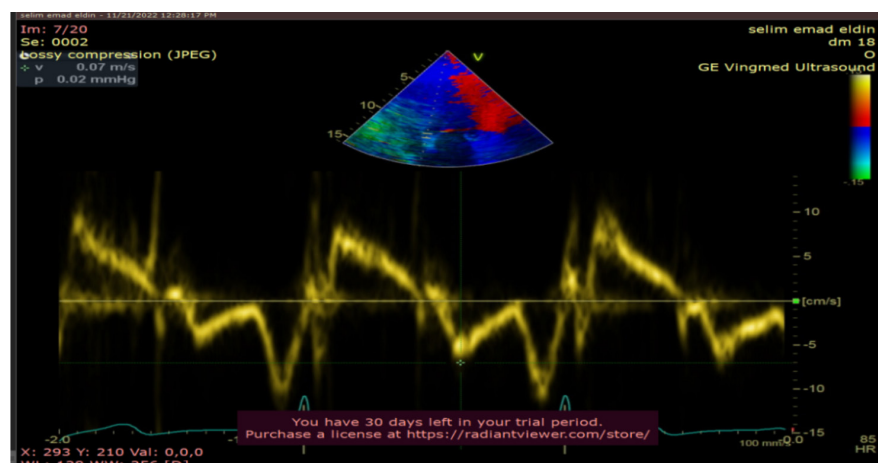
Tissue Doppler analysis of the septal mitral annulus to calculate septal e' in apical 4 chamber (follow-up study of patient number 8)
